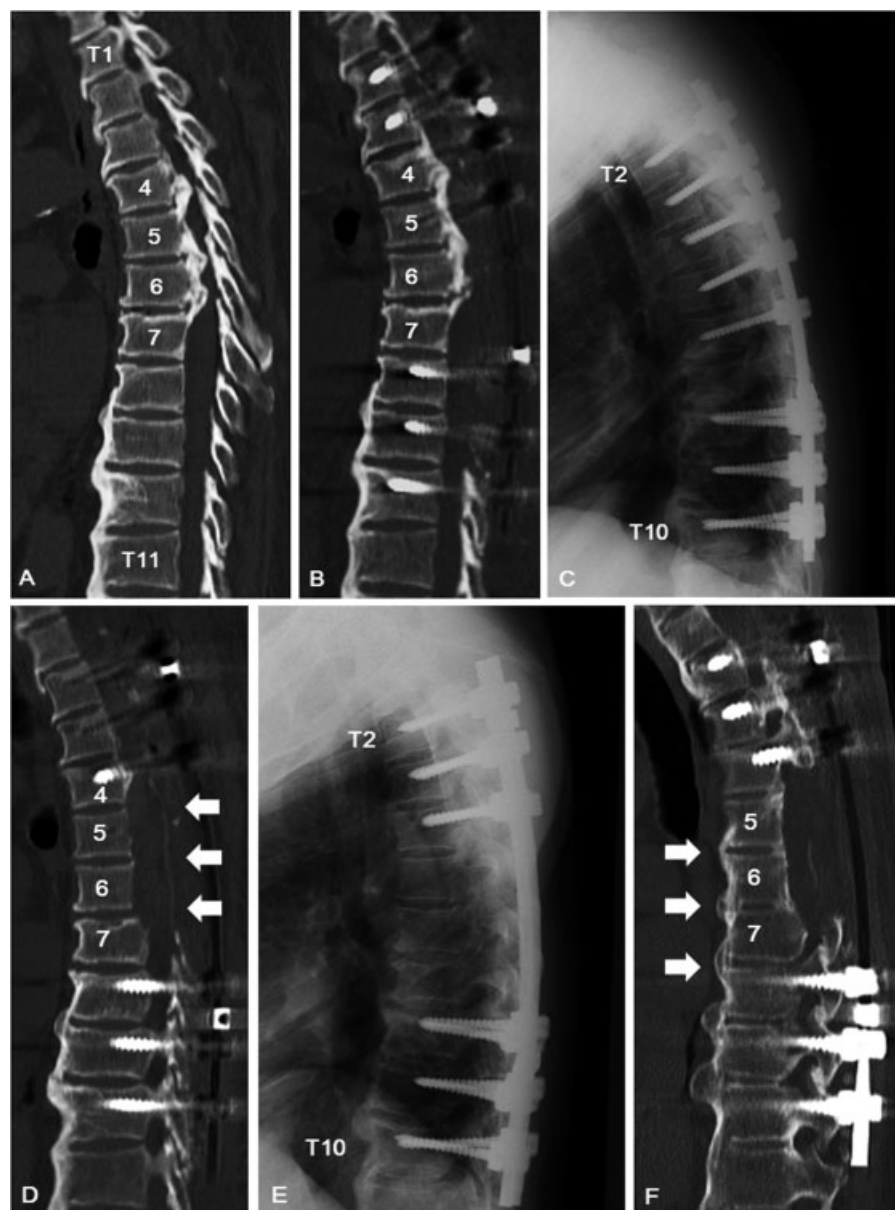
Case 2, a 61-year-old man. (A) Preoperative computed tomography (CT) sagittal image. (B, C) Lateral plain radiograph and CT sagittal image after posterior decompression and instrumented fusion (first surgery). (D, E) Postoperative lateral plain radiograph and CT sagittal image after resection at an anterior site of the spinal cord from a posterior approach (RASPA; second surgery, arrow). More thoracic dekyphosis was achieved after the second surgery than after the first surgery. (F) At final follow-up, the ossification of the anterior longitudinal ligament was also extended and fused, with stabilization of the thoracic spine (arrow).
